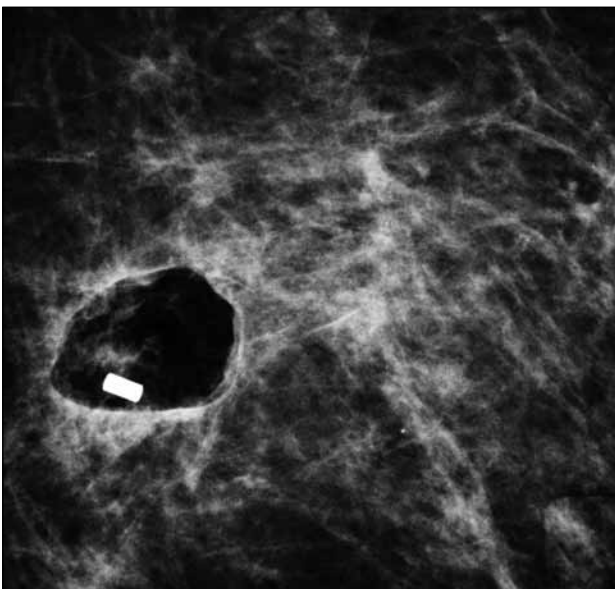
Post-procedural radiograph. An inert titanium metallic marker is deployed into the breast for biopsy-site identification, and the position of the marker was counterchecked in the post-procedural radiograph.
